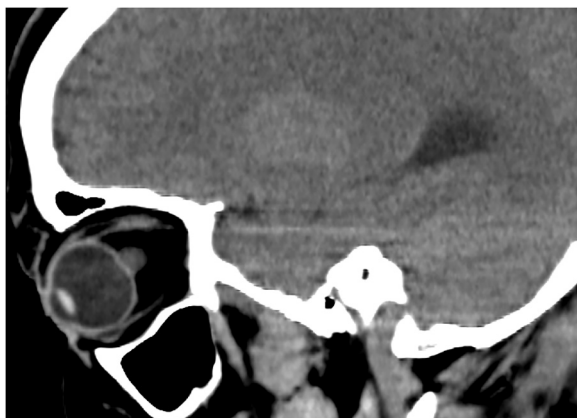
Post sub-occipital decompression, pre-ventricular shunting sagittal non-contrast CT image of the orbit demonstrate flattening of the posterior globe and some bulging of the optic disc into the back of the orbit. This suggests that the elevated intracranial pressure has persisted after sub-occipital decompression for the Chiari I malformation.
